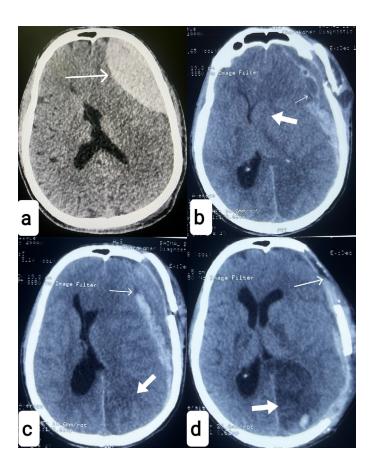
a) Axial section of CT scan of the head showing giant EDH on the left frontal convexity region (arrow) with midline shift, b) Axial section of postoperative CT scan of the head showing mixed density lesion (SDH) on the same side (thin arrow) and midline shift (thick arrow), c) Axial section of postoperative CT scan of the head showing SDH on the same location (thin arrow) with the PCA territory infarction (thick arrow), d) Axial section of postoperative CT scan of the head after second surgery showing residual subdural blood (thin arrow) with persisting PCA infarction (thick arrow)
